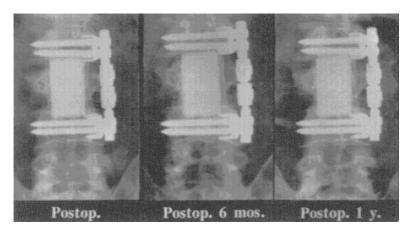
Radiographs of patient with burst fracture of lumbar vertebra (L3).
